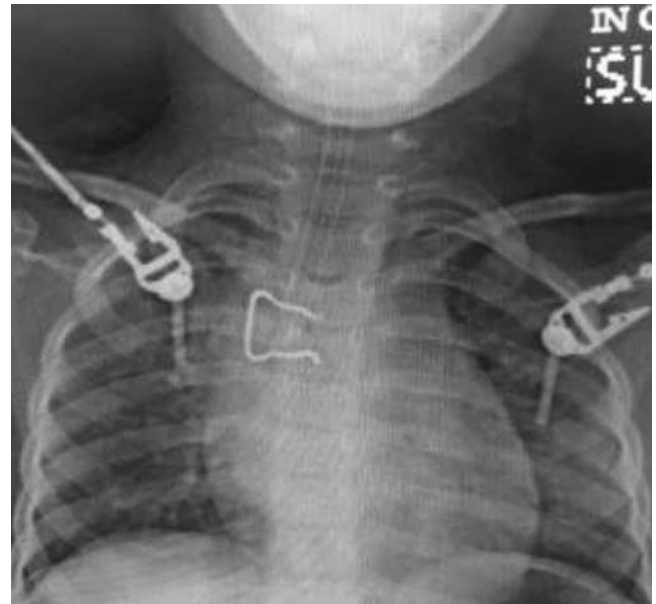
Radiograph of chest showing a curved metallic via endoscopy.
